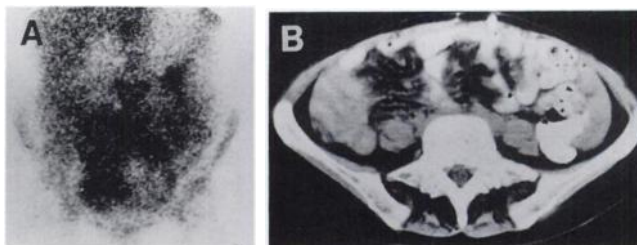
(A) Persistent and extensive abdominal radiogallium activity indicated active metastatic uterine leiomyosarcoma in a patient post-surgery and radiotherapy. (B) The CT scan of the patient seen in (A) was interpreted as being within normal limits.
